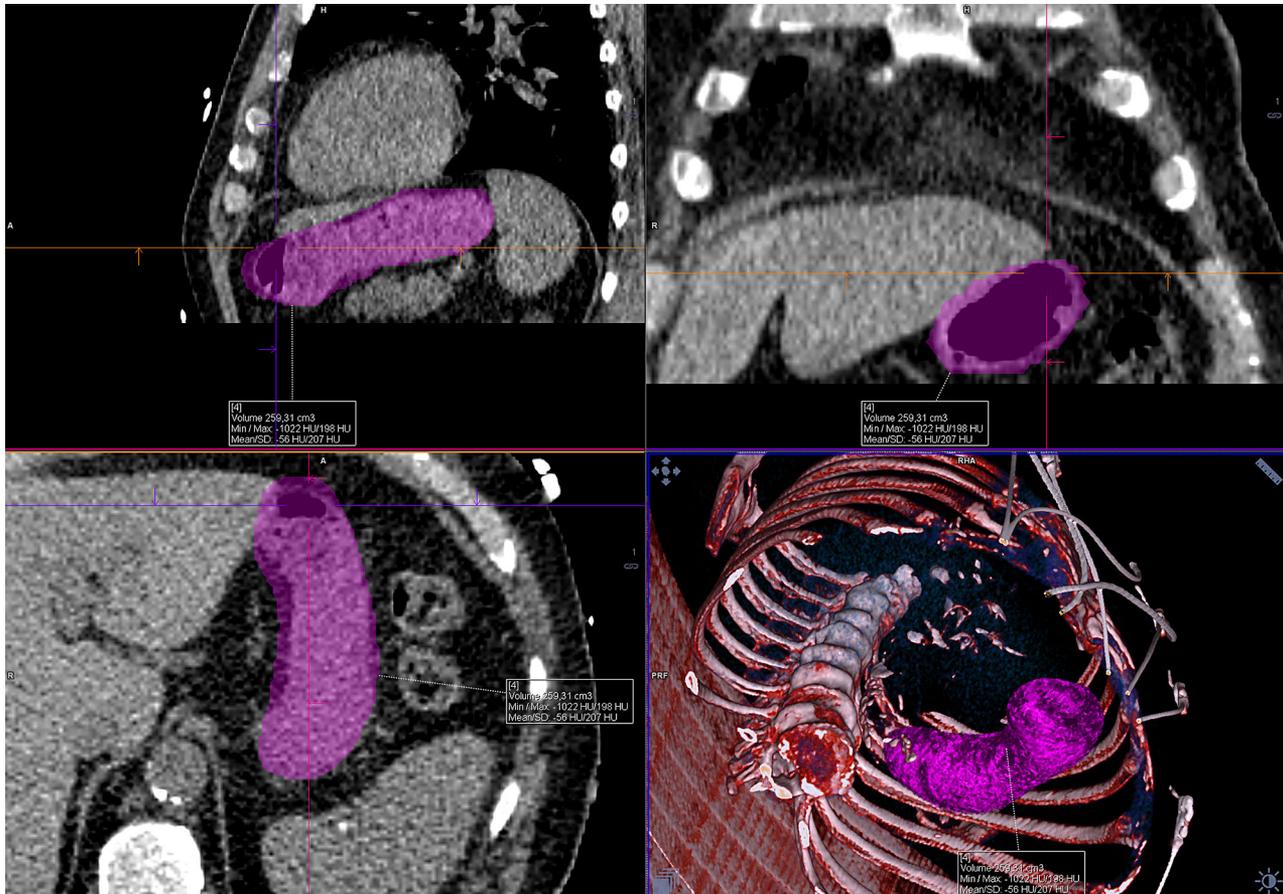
Representation of the stomach in computed tomography shown in transverse, sagittal, coronal, and 3D projection.
